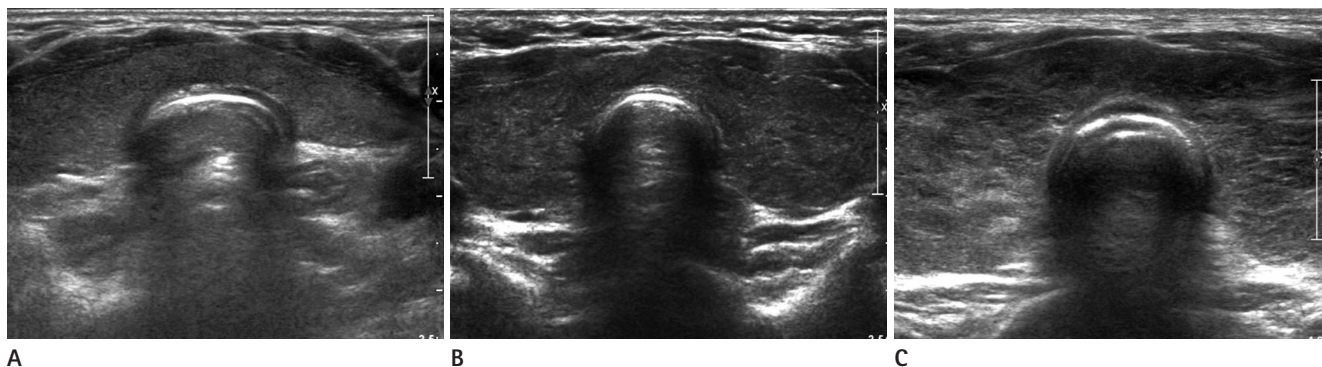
Ultrasound (US) of group 1, 2, and 3.
